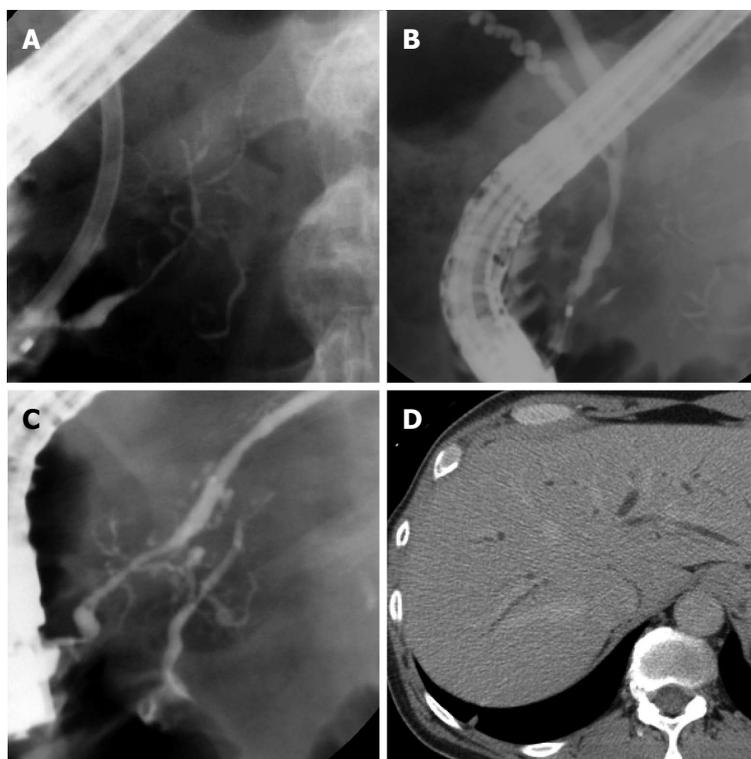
Biliary involvement in autoimmune pancreatitis. A, B, C: Endoscopic retrograde cholangiopancreatography demonstrating diffuse narrowing of the main pancreatic duct (A) and segmental narrowing of the lower common bile duct (B), with improvement of main pancreatic duct narrowing after therapy (C); D: Computed tomographic image demonstrating intrahepatic biliary ductal dilatation in a patient with biliary involvement from IgG4-related disease.
